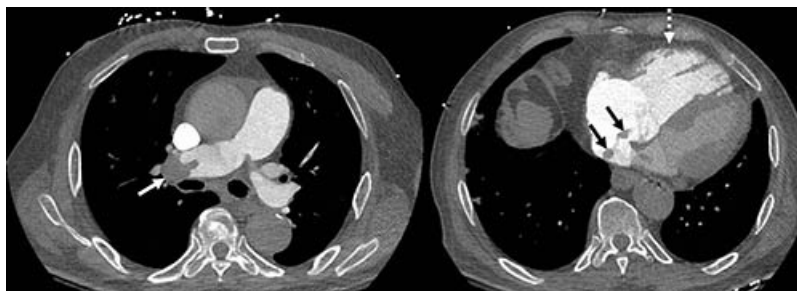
Acute pulmonary embolism (PE) with right ventricle (RV) enlargement and clot-in-transit. PE chest axial CT angiography images demonstrate pulmonary embolus in the right pulmonary artery (white solid arrow), an enlarged RV (dotted arrow), and thrombus transiting through the right atrium (black arrows), Pulmonary Embolism Reporting and Data System (PE-RADS) 4/RV+/T+. The “4” refers to the PE-RADS ordinal category for the most proximal clot location (central arteries). “RV+” indicates RV enlargement (RV to left ventricle ratio ≥ 1.0). “T+” indicates definitive thrombus identified in the right atrium and/or RV.
